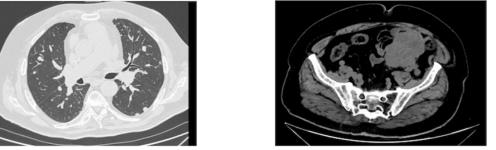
Computed tomography. A Multiple bilateral lung metastases B Pelvic mass, displacing small bowel intestine.
